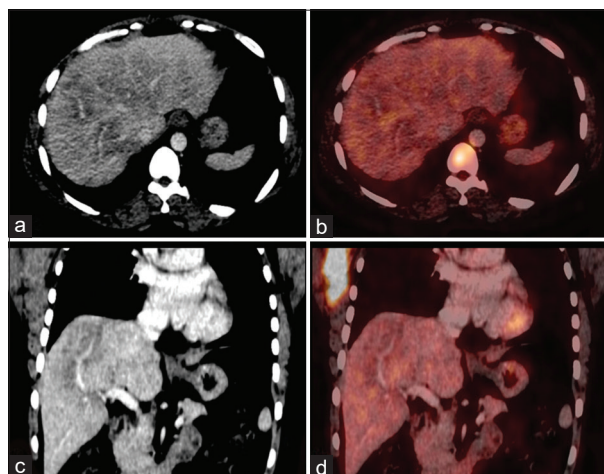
Axial computed tomography (a) showing avid confluent hypodense lesions without corresponding increased fluorodeoxyglucose uptake in the fused positron emission tomography/computed tomography (b). Coronal computed tomography (c) and fused positron emission tomography/computed tomography (d) showing these hypodense lesions along the portal tract
